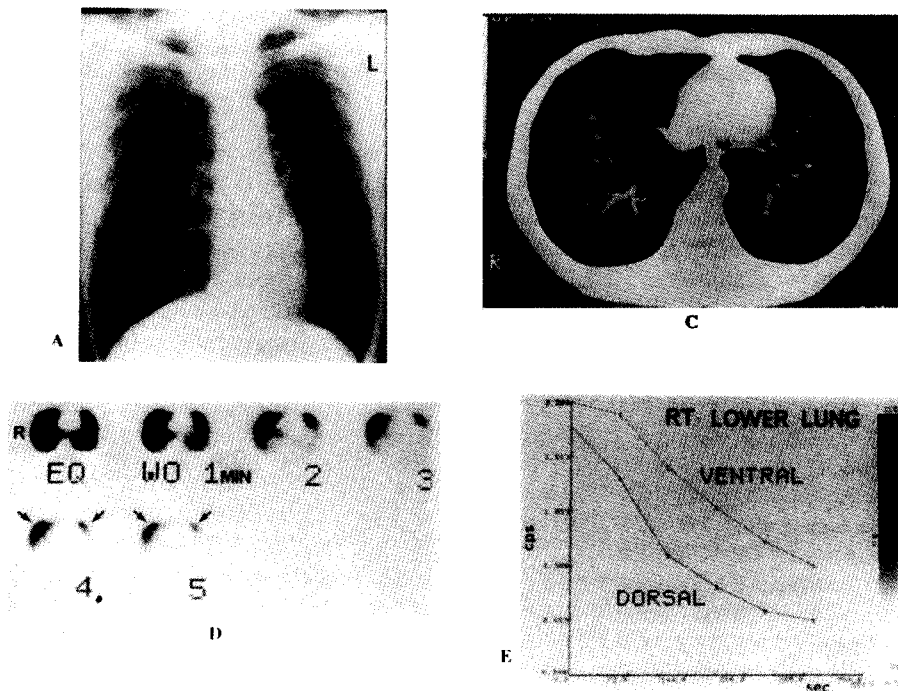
¹³³Xe SPECT of emphysema. The washout delay of ¹³³Xe gas in the peripheral area is clearly seen (as shown by arrows in the panel D).
